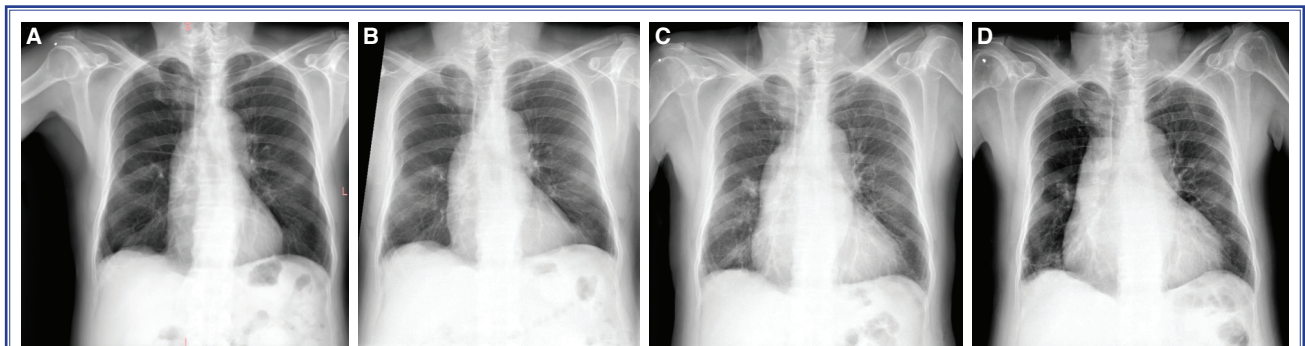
Chest X-rays revealing progressive increment in mediastinal diameter beginning in 2010 (A) through 2013 (B), 2014 (C), and 2016 (D).
